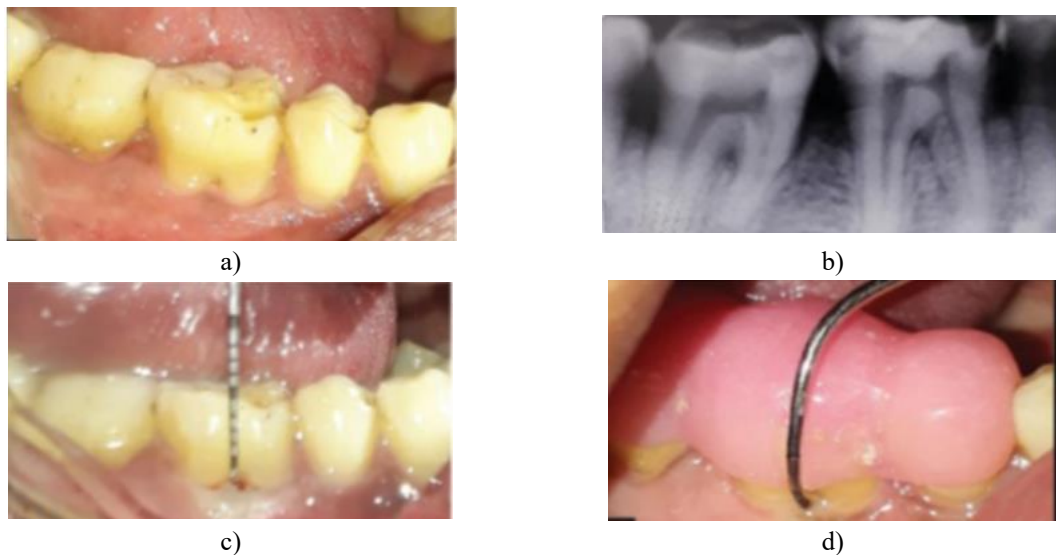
(a) Pre-operative image of control site, (b) Pre-operative intraoral periapical radiograph of the tooth with grade II furcation, (c) Presurgical vertical probing depth measurements, (d) Presurgical horizontal probing depth measurements
